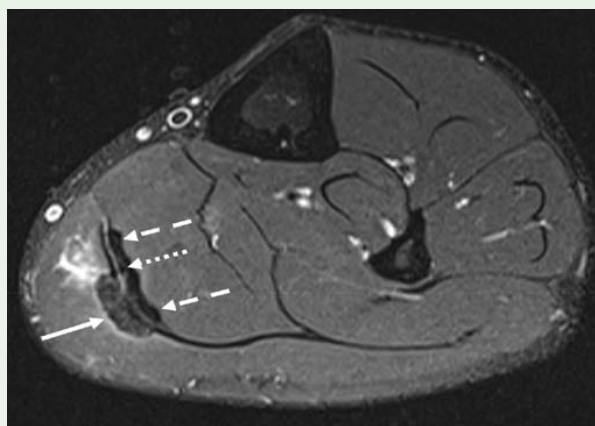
Axial T2-FS left calf MRI at the same level 6 months following the previous injury showing thick maturing scars of the medial soleus and gastrocnemius aponeuroses. There has been clinically recurrent medial calf injury between scans, explaining the higher signal and thicker MHG scar (arrow) relative to the soleus scar (dashed arrows). There is a small recurrent MHG tear at the medial aspect of the scar, accounting for the acute presentation. The plantaris tendon (dotted arrow) is adherent to the soleus aponeurosis scar. Subsequently the player was not able to progress in rehabilitation due to inability to sprint >80% and calf adhesiolysis was performed with 20cc normal saline. There was improvement in knee to wall from 11.5cm to 12cm. Repeat adhesiolysis with 15cc normal saline was performed at 3 weeks for recurrent medial calf 'tightness' and full training was resumed at 1-week post procedure.
